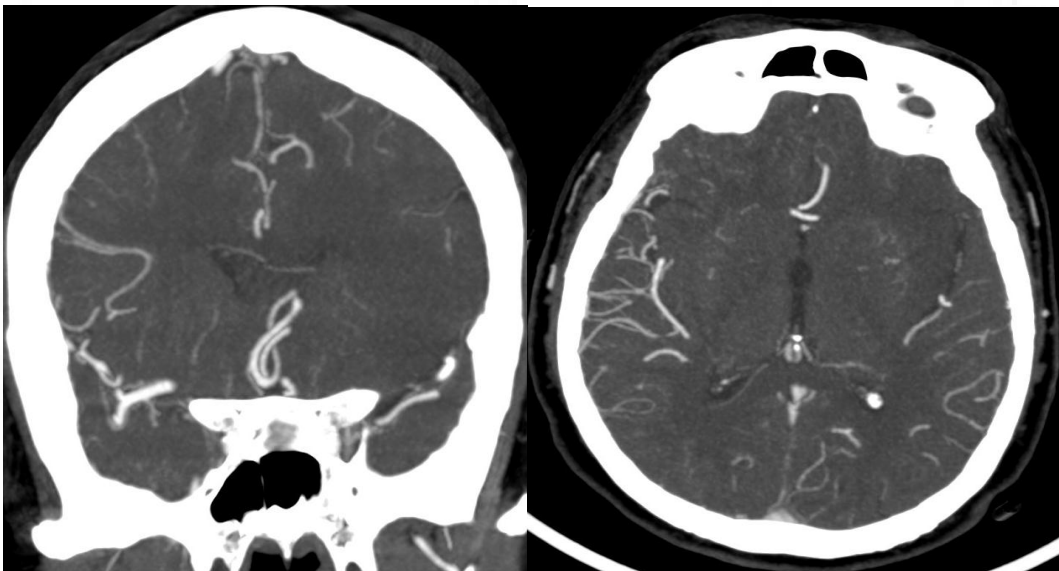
Coronal CT MIP single phase showing poor collateral score (TAN grade 1)
